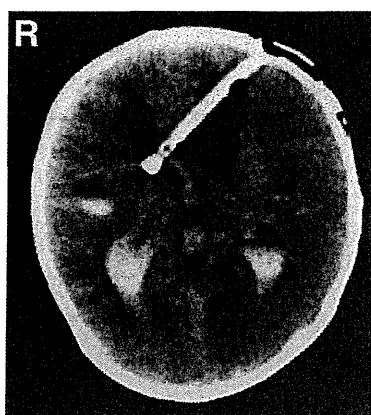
Case 1. Postoperative computed tomography scan showing improvement in hydrocephalus, but an extensive ischemic lesion in the left hemisphere.
